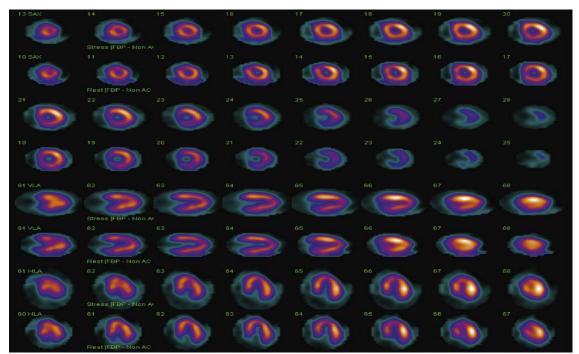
shows Normal myocardial SPECT perfusion study. Top four rows display the short-axis transaxial images (stress above, rest below), fifth and sixth rows display the horizontal long-axis (sagittal) stress and rest views, and the seventh and eighth rows display the vertical long-axis (coronal) views.
